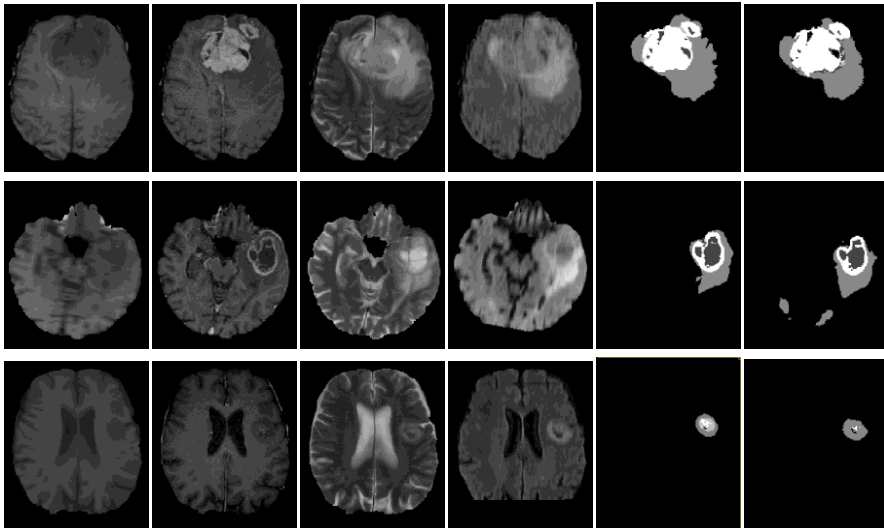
Three examples of tumor segmentations. From left to right, in the columns are the database MRI sequences: T1, T1-contrast, T2 and Flair, the provided manual segmentation and the automatic segmentation, respectively. First row shows the best result achieved (HG0015), second row shows an image with evaluation close to the mean (HG0022), third row corresponds to the worst segmentation (HG0012).
